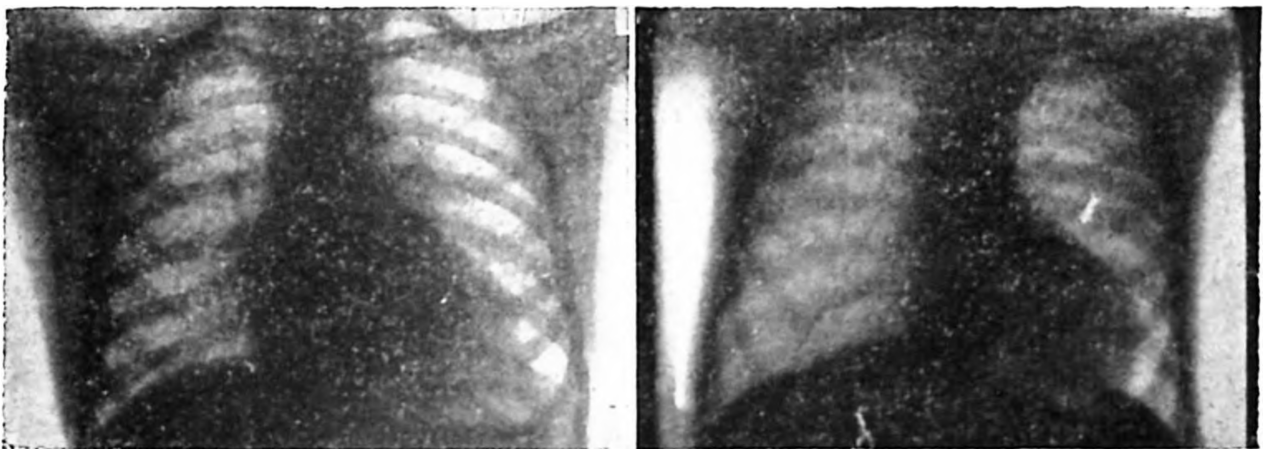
Roentgenograms taken before (right) and after (left) the Blalock shunt operation in a patient with tetralogy.
